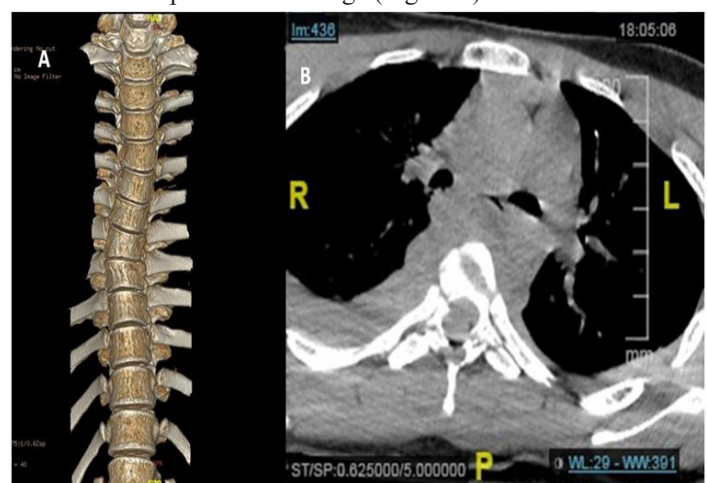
CT images: A. Kyphoscoliotic deformity. B. Bilateral pedicle fracture and body fracture seen at T6 level.
